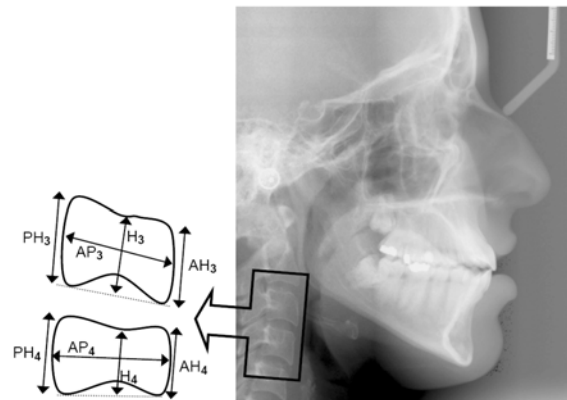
Measurements performed to calculate the cervical vertebral bone age on the third and fourth cervical vertebrae (C3, C4) appearing on lateral cephalometric radiograph. AH, distance from the most superior to the most inferior point on the anterior surface of the vertebral body; AP, maximum anteroposterior distance at the middle of cervical vertebral body; H, distance from top of the middle part of the vertebral body to a tangent connecting the most inferior points of the lower border; PH, distance from the most superior to the most inferior point on the posterior surface of the vertebral body.
